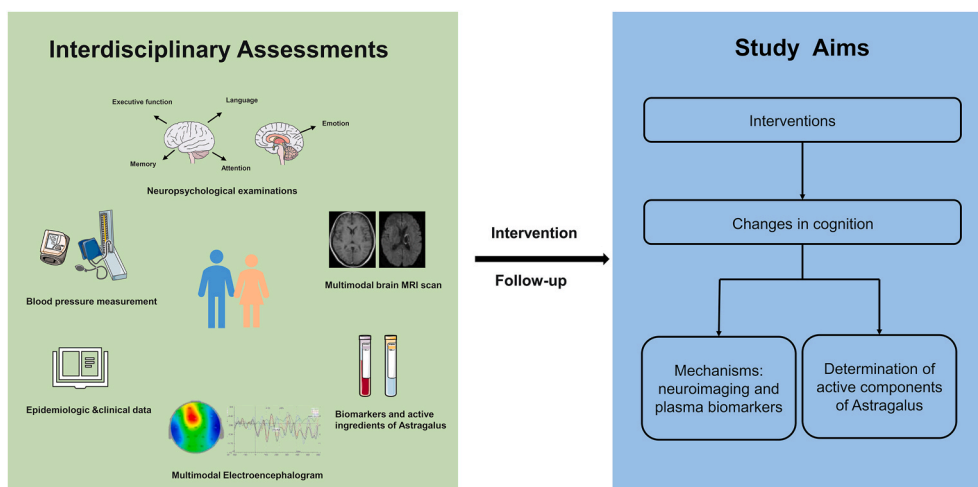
This clinical trial examines whether AM improves cognitive and non-cognitive symptom in patients with of mild to moderate AD complicated with OH. Abbreviation: AM, Astragalus membranaceus; AD, Alzheimer disease. MRI, magnetic resonance imaging.
